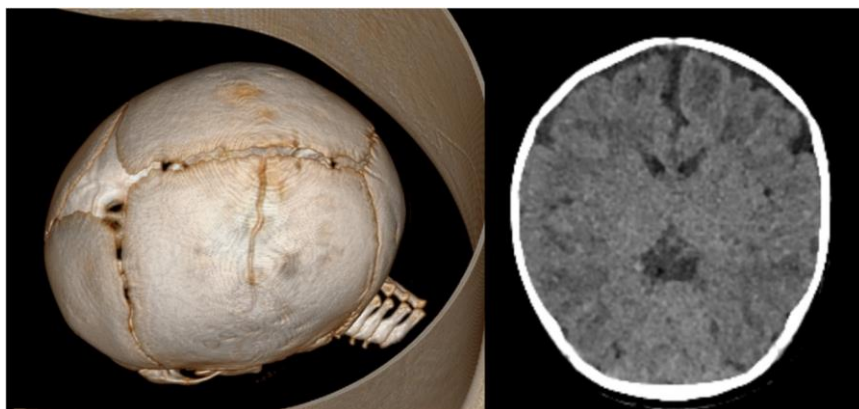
CT scan of a 1-month-old female infant showing a linear parietal skull fracture following accidental domestic trauma, without associated intracranial hemorrhage.
